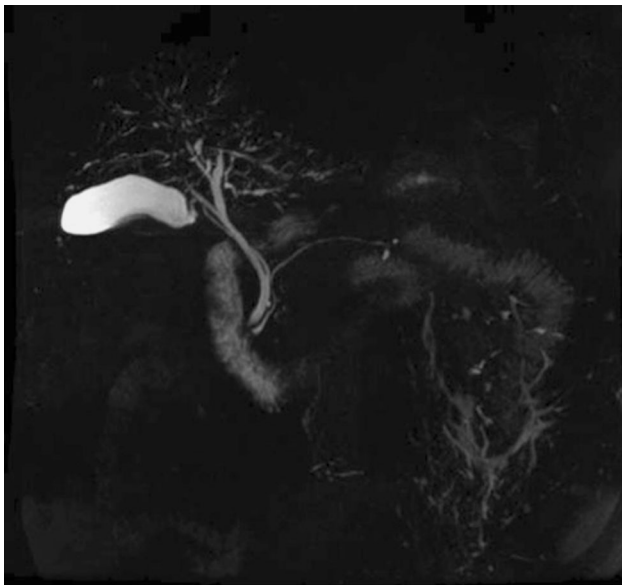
MRI demonstrating continued multifocal narrowing and dilatation of intrahepatic bile ducts, including peripheral bile ducts, with the appearance of sclerosing cholangitis
